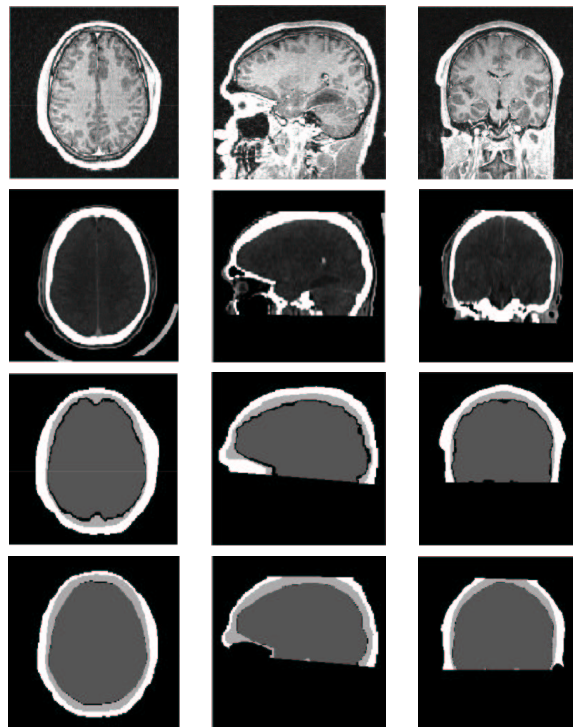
Segmentation of brain, skull and scalp from MRI and its corresponding CT on transaxial, sagittal and coronal slices respectively. First Row: Original MR image. Second Row: Original CT data. Third Row: Segmentation of brain, skull and scalp from MRI. Fourth Row: Segmentation of brain, skull and scalp from CT.
